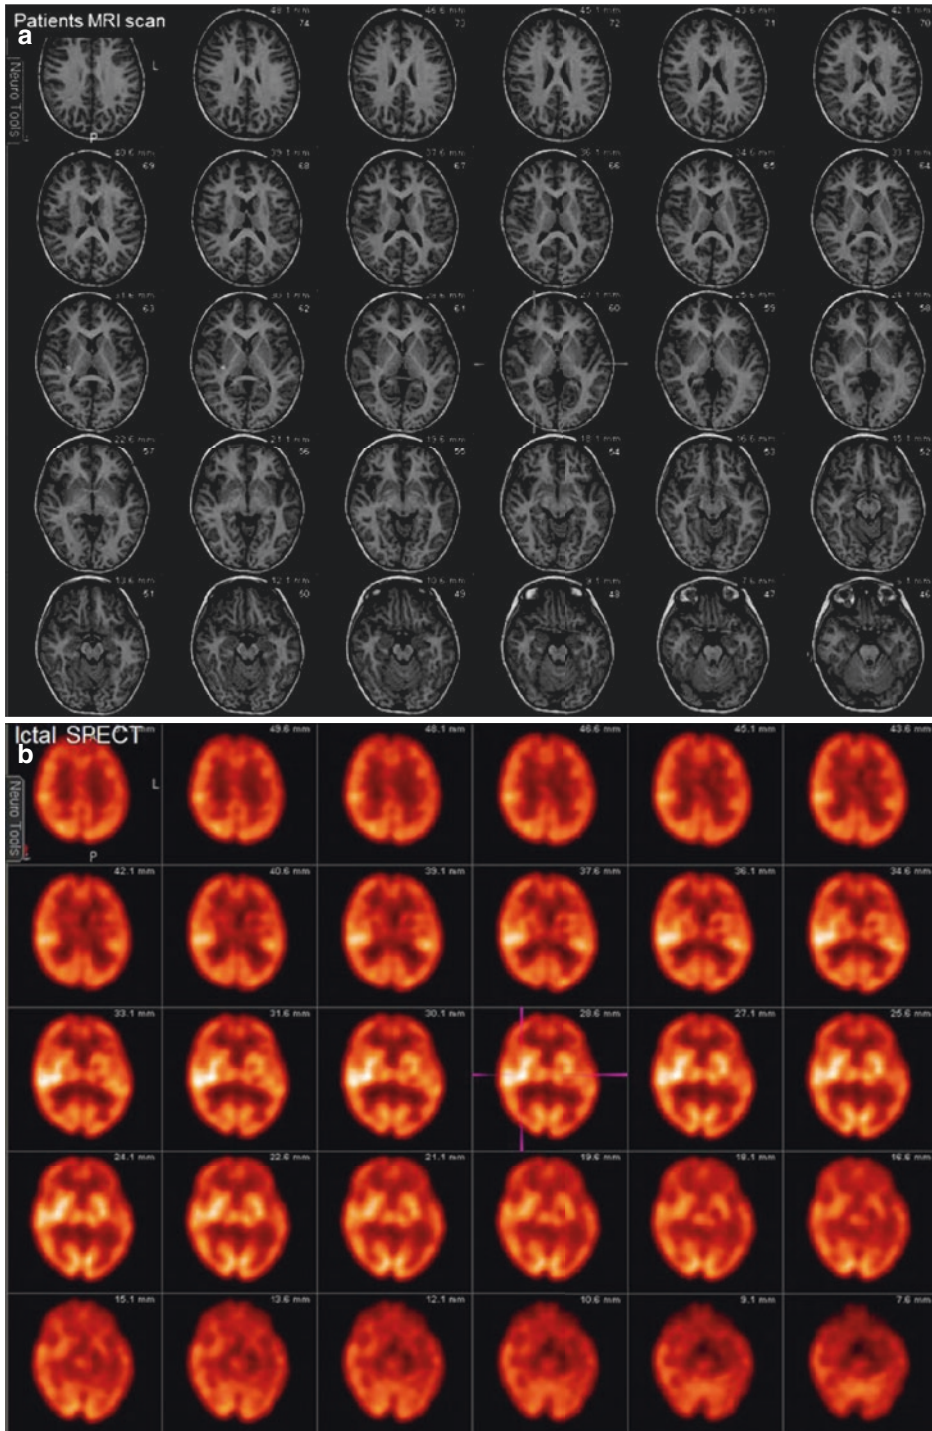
(a–e) Patient with history of intractable complex partial epilepsy for 2 years presents for evaluation localization of epileptogenic focus. Seizure semiology reveals unusual scream during sleep appears scared and hallucinating and seeing objects. Daily nocturnal seizures average from two to up to eight per night. (a) MRI findings
